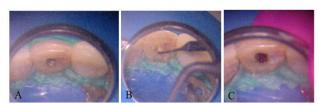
A - Root canal access with filling material localization. B - Removal of filling material using the Clearsonic Black R1 ultrasonic insert. C - Clinical appearance of the lesion area after removing the resorption tissue. Source: authors, 2025.
